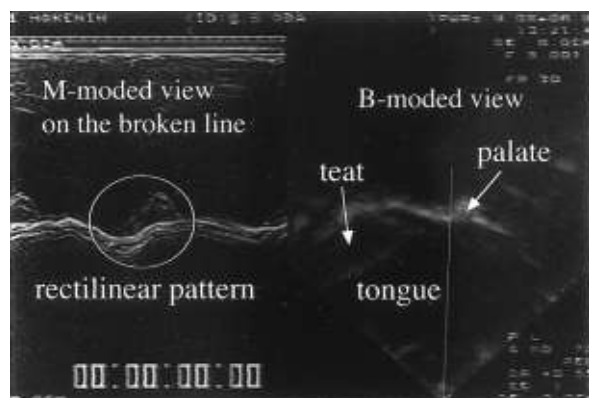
B-mode and M-mode ultrasonograms of normal neonates presenting the rectilinear pattern that indicates the sequential changes in the volume of the space formed by the tongue, palate, and nipple.
